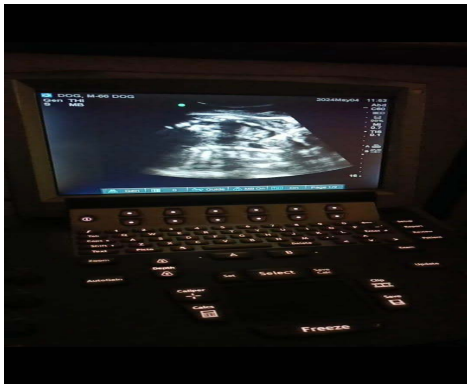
Ultrasonographic examination showing the presence of fetus with prominent ribs
